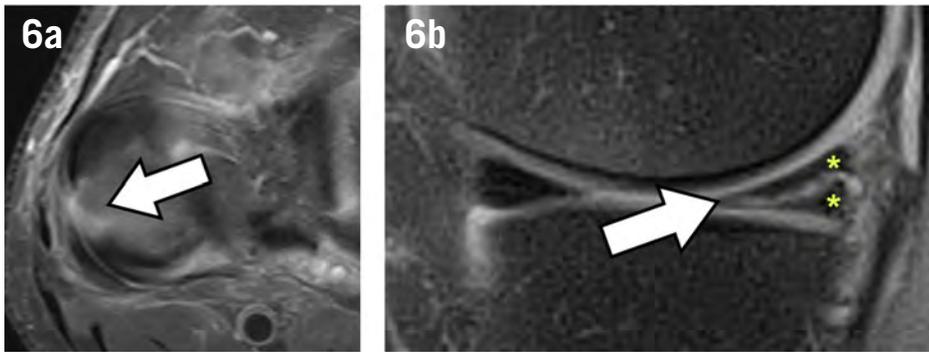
Magnetic resonance imaging of meniscal tears. Axial T2 weighted image (a) of the lateral femorotibial compartment showing a complete radial tear in the body of the lateral meniscus, as a complete discontinuity perpendicular to the long axis of the meniscus (arrow). Cropped sagittal T2 weighted image (b) of the medial femorotibial compartment showing a horizontal tear in the posterior horn of the medial meniscus, as a linear high-signal abnormality (arrow) along the long axis of the meniscus that divides the meniscus in one superior and one inferior fragments (asterisks).
